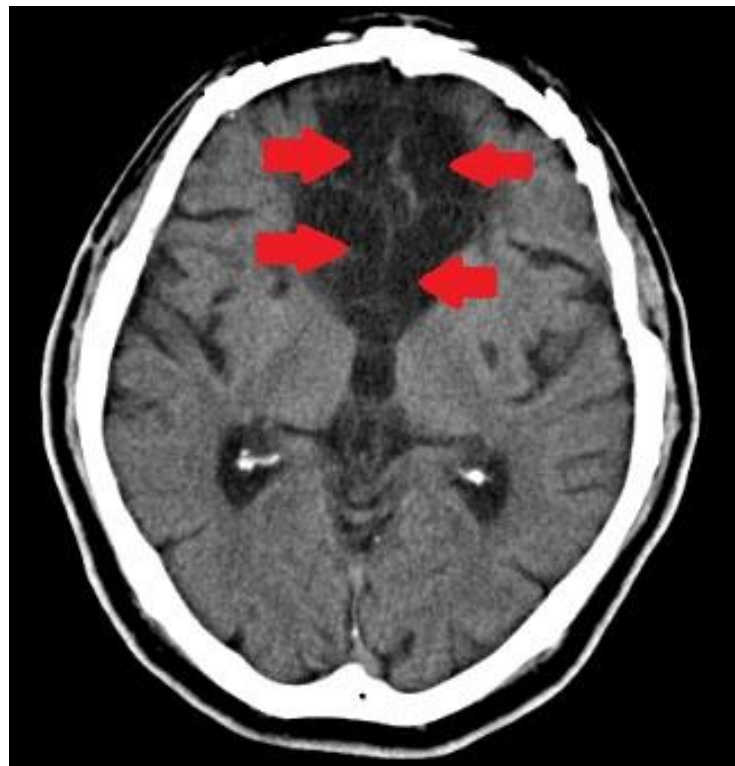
CT shows individual fluid-filled compartments form (red arrows).
